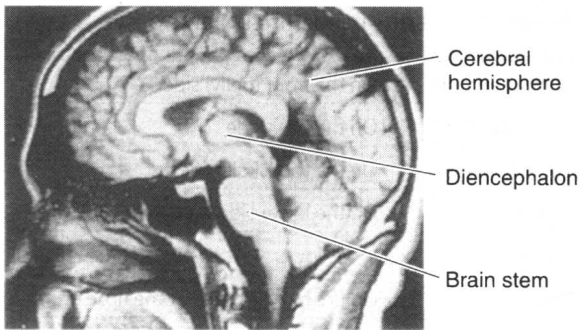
Magnetic resonance image of a midsagittal section through the head (short time sequence; see Chapter 22). Compare with Figure 1-2.
